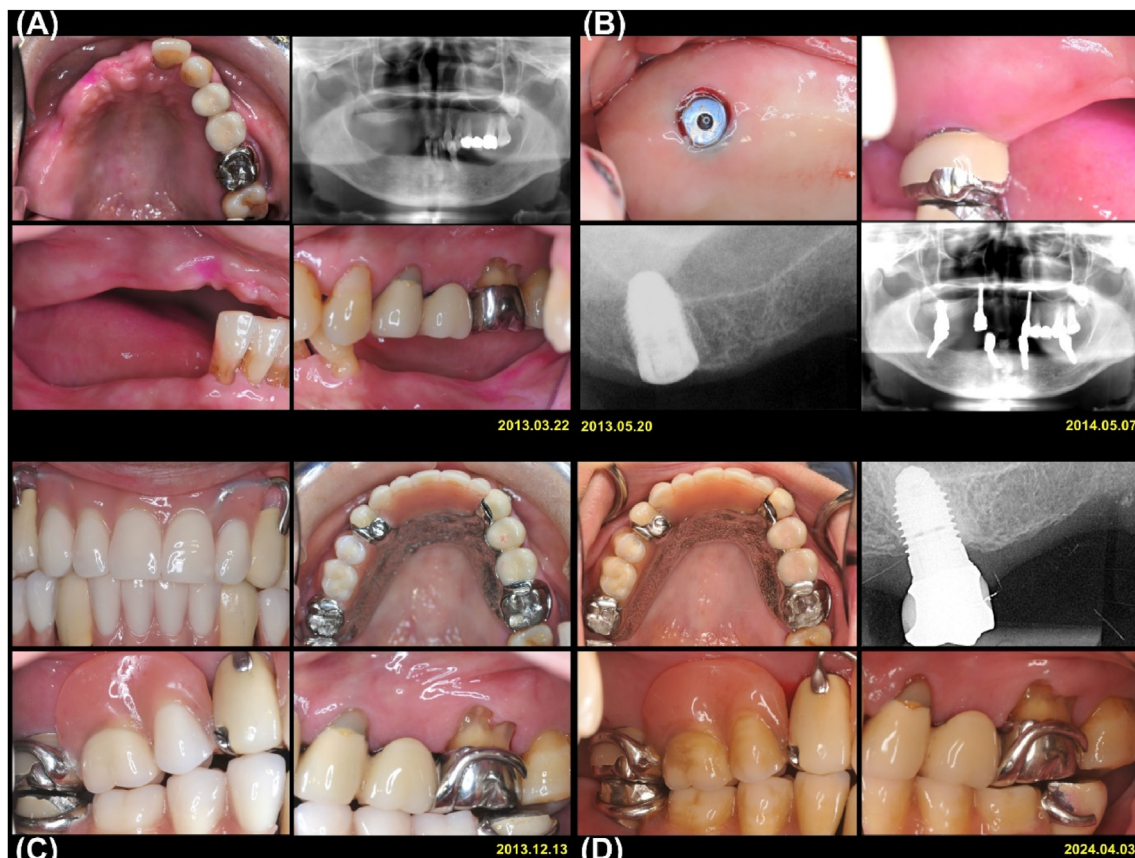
Clinical photographs and radiographs of our patient. (A) A 58-year-old female patient with a Kennedy Class I partial edentulous maxillary arch. (B) Implants were placed and restored at positions #14 and #17 (6 × 10 mm), aiming to transition the removable partial denture (RPD) from Kennedy Class I to a more favorable Kennedy Class III. (C) Horseshoe major connector was designed due to prominent palatal median suture. I-bars at implants #14 and #23 and circumferential clasps at implants #17 and #26 were used to provide RPD retention. (D) Ten years after denture delivery, clinical and radiographic examinations revealed the minimal marginal bone loss and minimal marginal tissue recession at implant #17.
